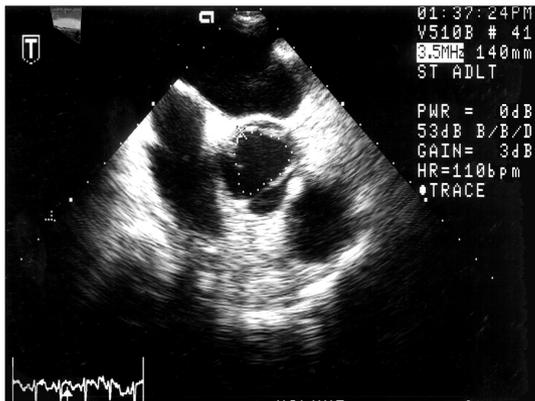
An example of cross-sectional images of aorta and aortic valve obtained intraoperatively by transesophageal echocardiography.
